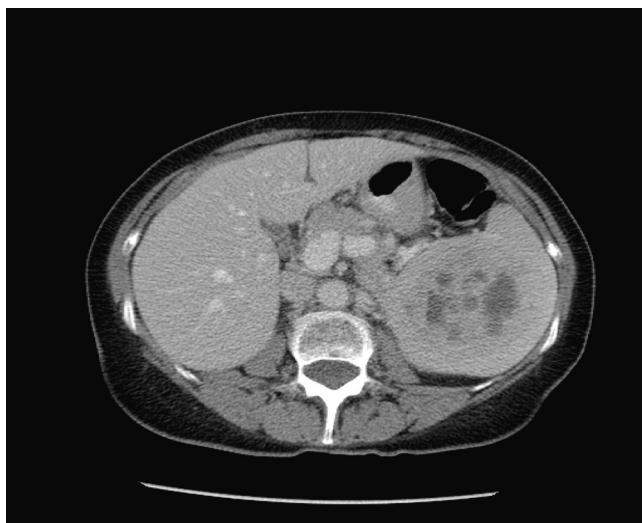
Axial CT image showing splenic mass.
